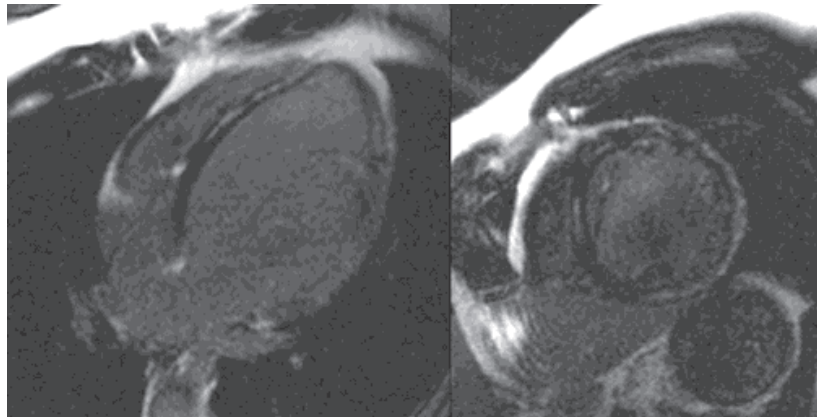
Cardiac magnetic resonance imaging of acute myocarditis in a adolescent. In four chamber and short axis view, subepicardial late enhancement are noted. Text and image courtesy of Alper Yuksel, Yigit Goktay.
